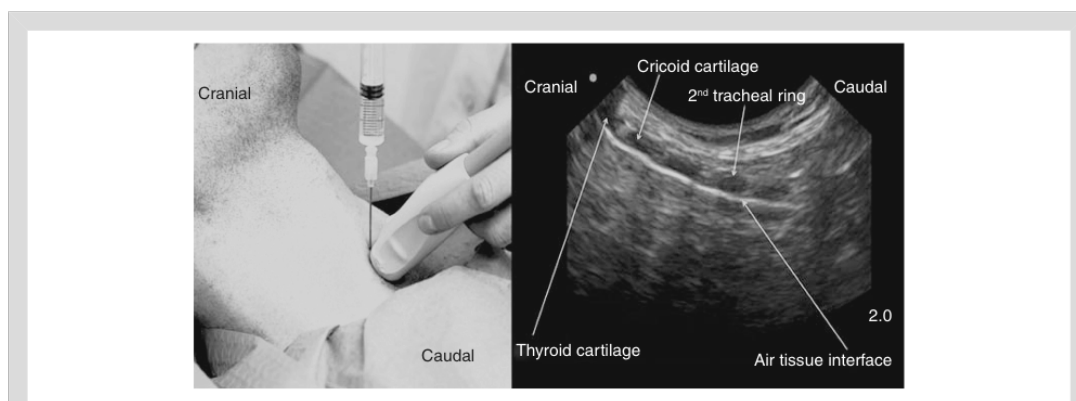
Photo of the position of the probe and needle (photo taken on a model instead of a cadaver, published with consent), and corresponding ultrasound scan in a longitudinal axis with the probe placed in the suprasternal notch. This figure shows how the trachea lies deeper the more distally the puncture is performed. The echogenic line is consistent with an air-tissue interface at the anterior wall of the trachea. The cartilages are echoluent; the posterior wall of the trachea is not visible.
